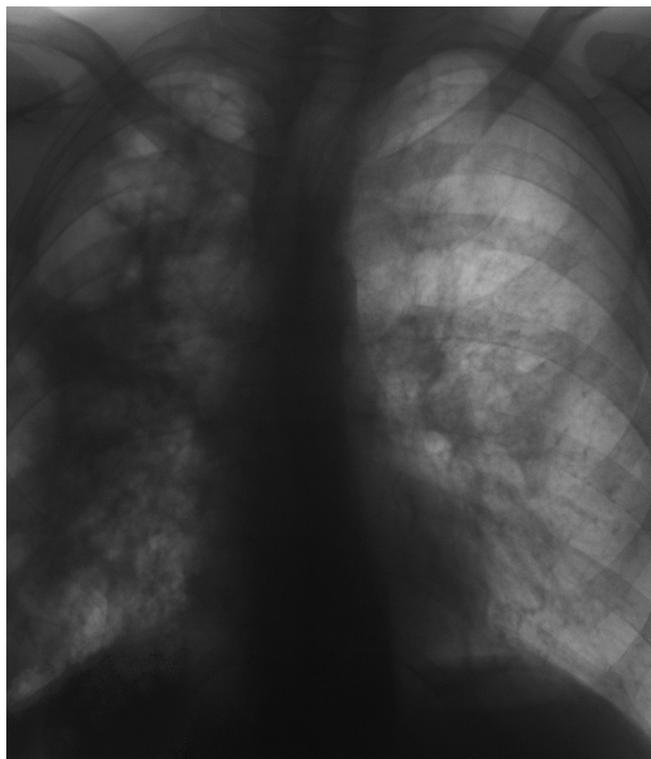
Chest X-ray on hospital admission
